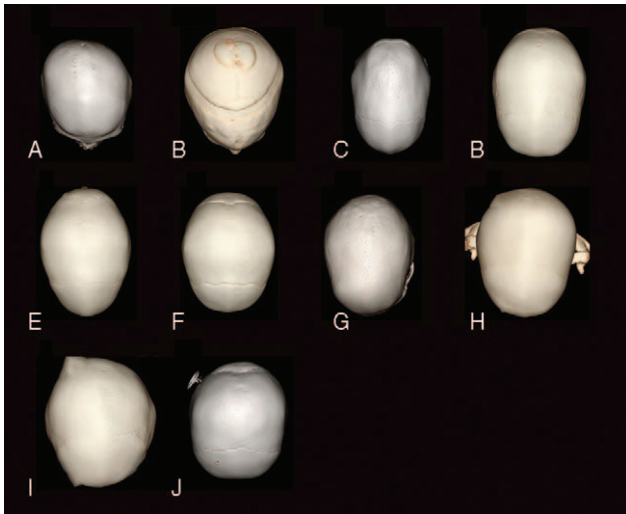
(A–J) Three-dimensional computed tomography calvarial reconstructions of patients 1 to 10 (as described in Table 2) presented sequentially.
